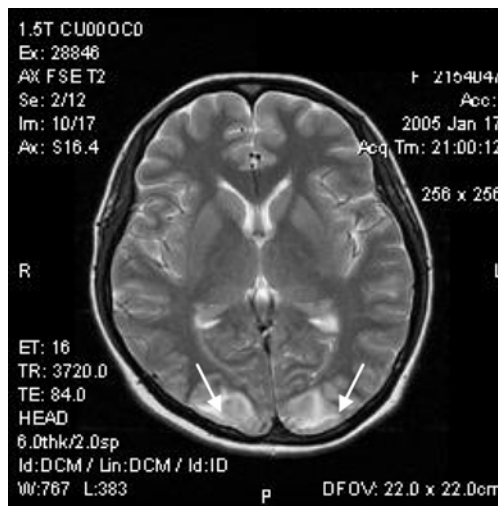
Classical RPLE: T2-weighted MRI of patient 8, the images showed symmetric hypersignal intensity at bilateral occipital areas (arrow)
